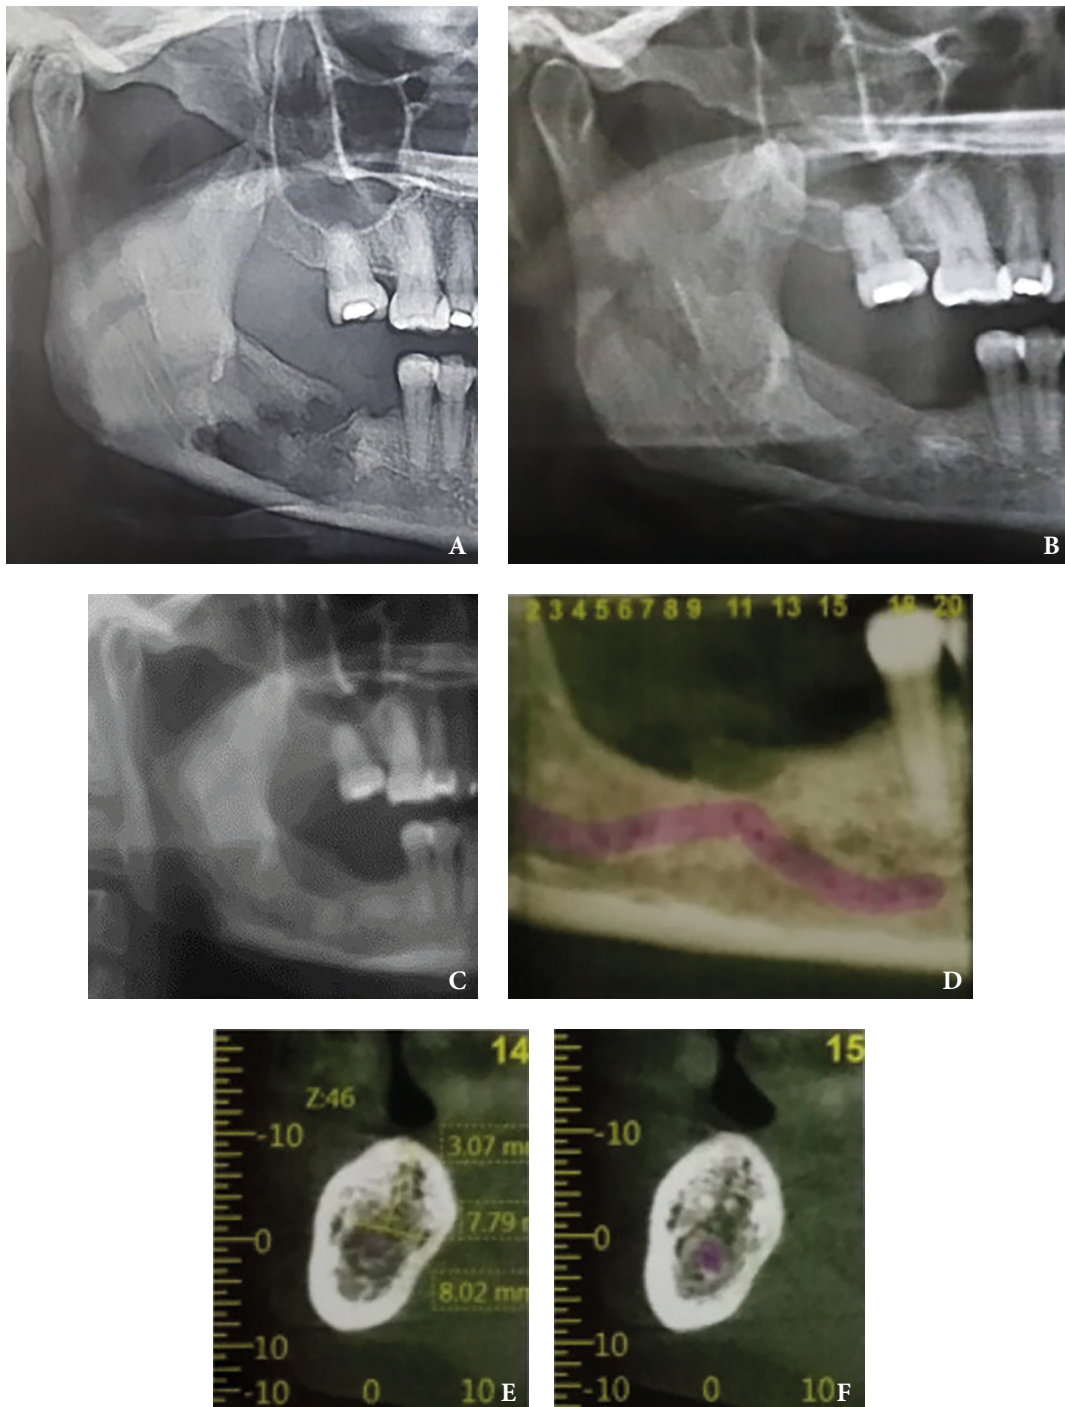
Case 5. A: 3 months post-op. B: 6 months post-op. C: 1 year post-op. D-F: CT scans 3 years later show absence of injury, adequate corticalization and bone formation, continuity of the inferior alveolar nerve.
